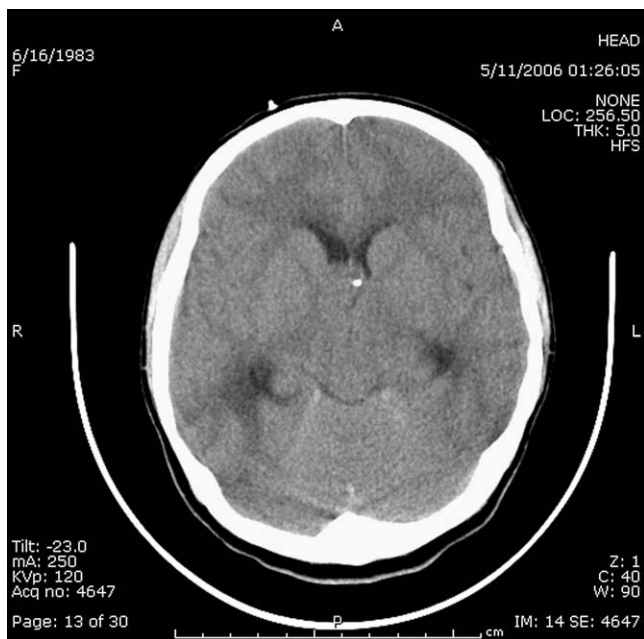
Noncontrast CT image demonstrates a mass near the foramen of Monro in the right lateral ventricle. A ventriculostomy catheter is situated adjacent to the mass.
